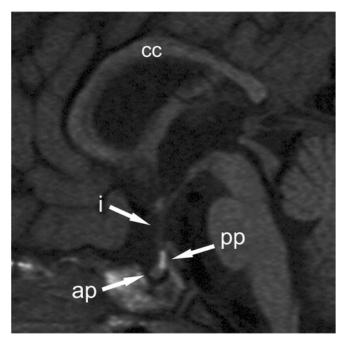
Midline sagittal MRI section of patient 1 showing hypoplasia of the anterior pituitary (ap), normal infundibulum (i), with an eutopic posterior pituitary (pp) and a thin abnormal corpus callosum (cc).
